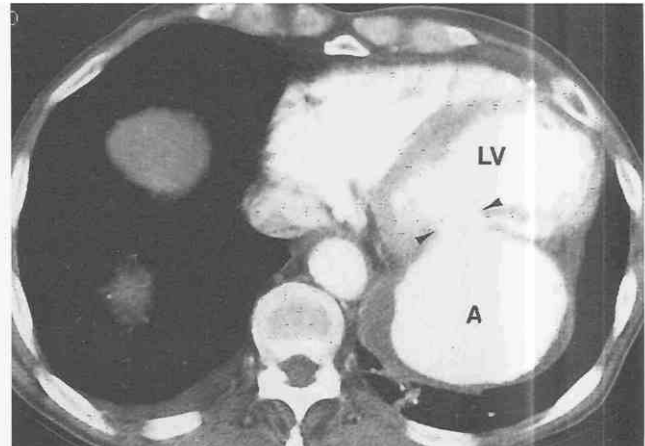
Left ventricular pseudoaneurysm. Contrast-enhanced CT shows a large pseudoaneurysm arising from the posterior wall of the left ventricle. A narrow neck (*arrowheads*) between the pseudoaneurysm (A) and the left ventricular cavity (LV) is seen.
